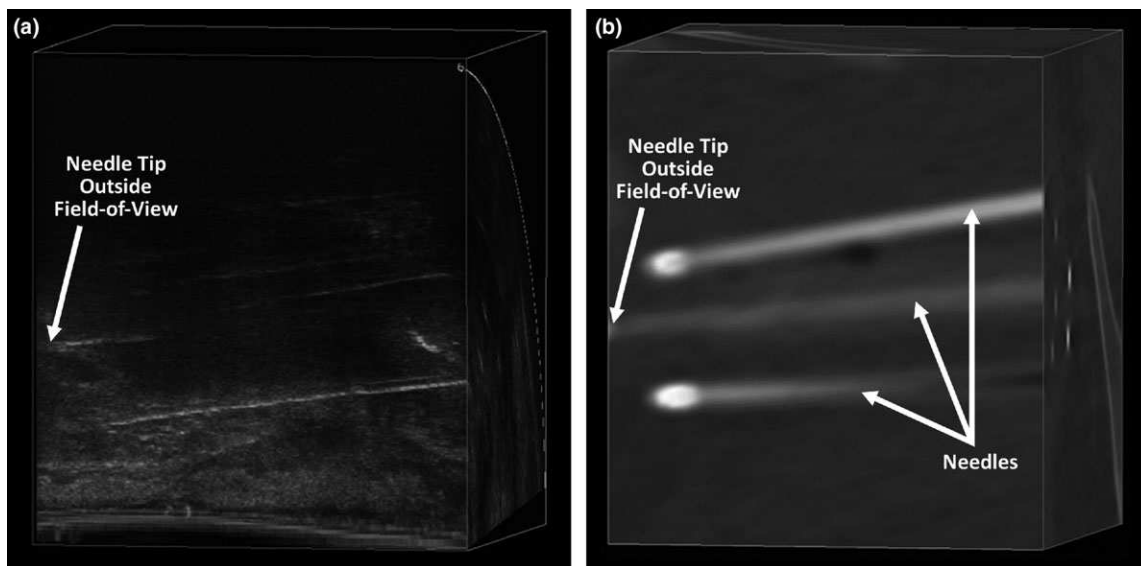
(a) 3D TRUS patient image showing the centermost needle extending beyond the image field-of-view, making the needle tip unidentifiable. (b) The corresponding, registered CT scan, showing the centermost needle tip extending beyond the image field-of-view.
